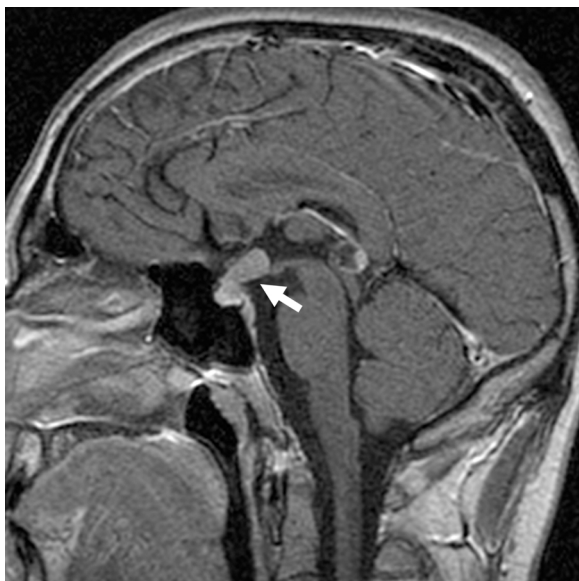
Sagittal spin-echo (SE) T1-weighted (T1w) acquired after i.v. administration of gadolinium (+Gd) demonstrating a solid enhancing mass (arrow) that extends from the pituitary fossa to the chiasmatic cistern displacing the optic chiasm.
